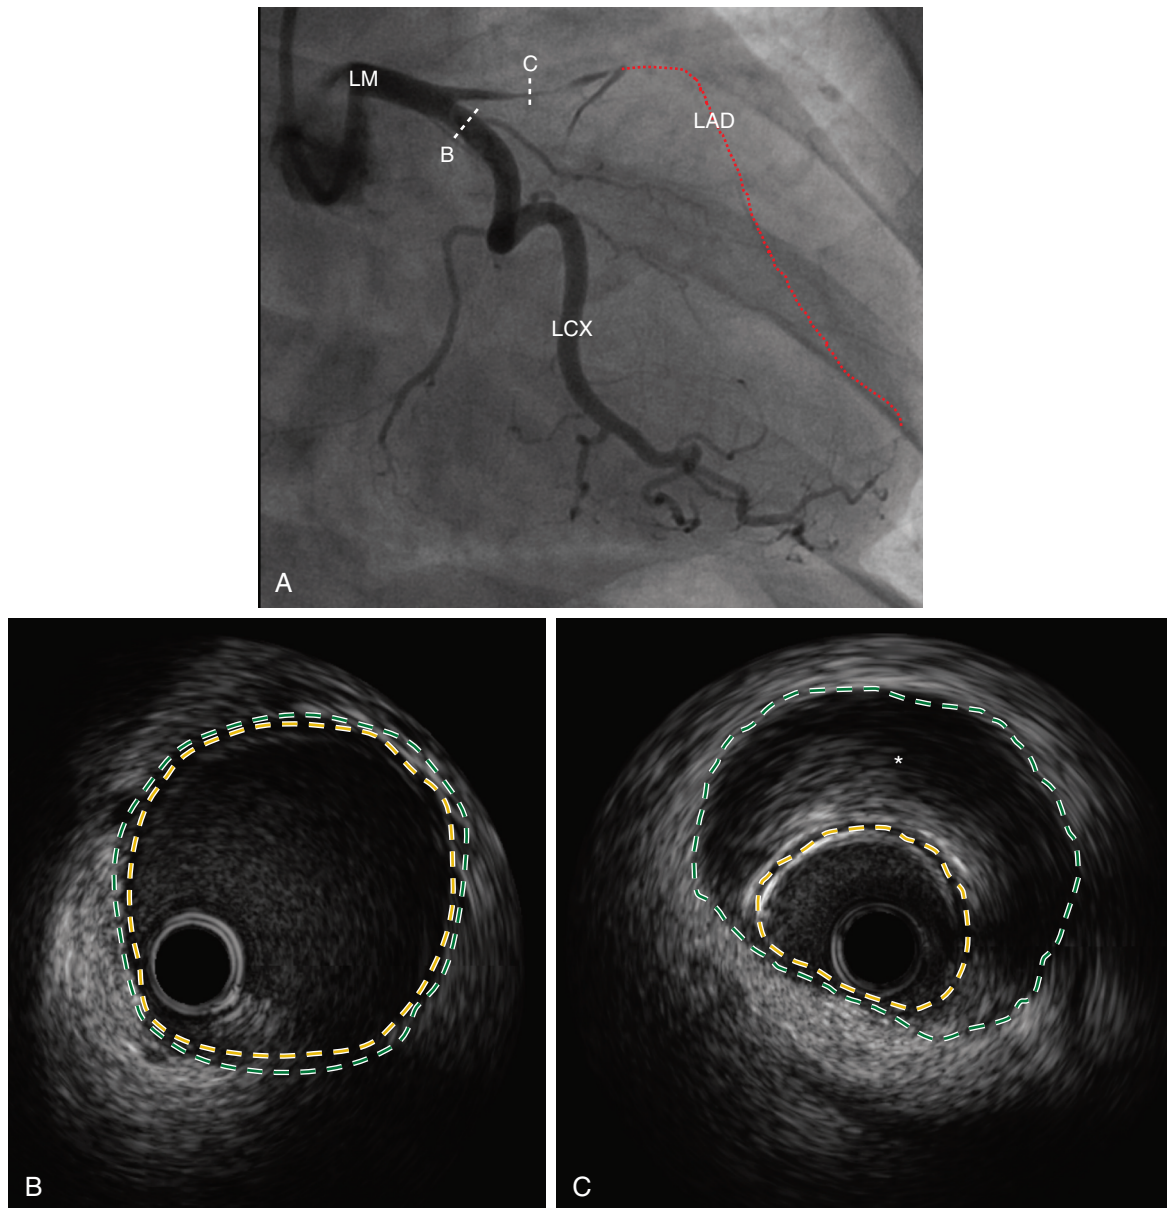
■ A, Coronary angiography in a 42-year-old postpartum woman in the right anterior oblique caudal projection demonstrating severe spontaneous coronary artery dissection of the left anterior descending coronary artery (LAD). The *dashed line in red* represents the course of the left anterior descending artery. *Dotted lines in white* mark the locations of the accompanying intravascular ultrasound (IVUS) images of the normal left circumflex coronary artery (LCX) and the dissected LAD. B, Intravascular ultrasound of the normal LCX. Green dotted line outlines the adventitia; yellow dotted line outlines the intima. C, Intravascular ultrasound of the dissected proximal LAD demonstrating large intramural hematoma (*asterisk*) between the intimal (*yellow dotted line*) and the adventitial (*green dotted line*) vessel layers, compressing the vessel lumen. LM, Left main.
